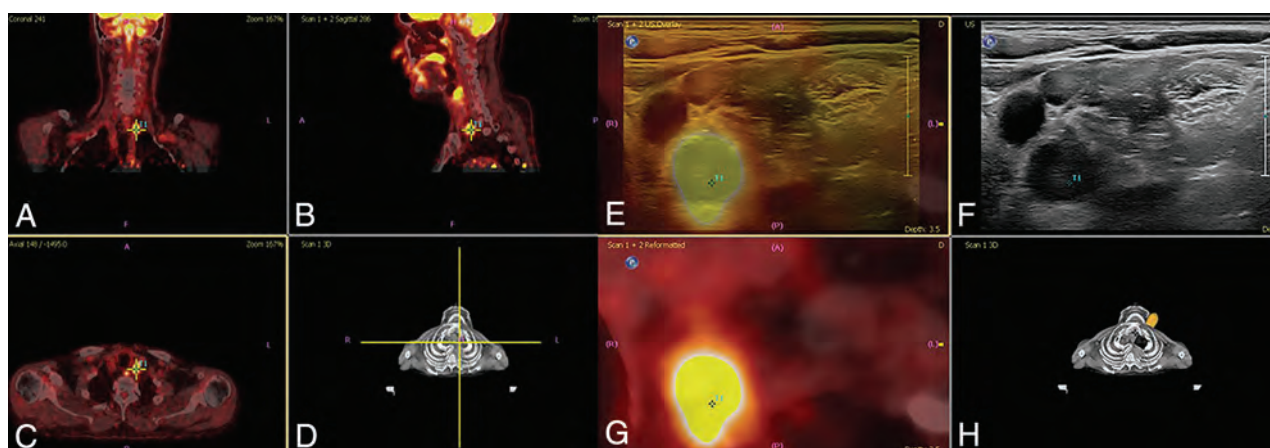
Target planning and real-time fusion of FDG-PET-positive lymph nodes to identify PET-positive nodes. A, Coronal view. B, Sagittal view. C, Axial view. D, Volume representation of FDG-PET/CT image and probe location, PET-positive nodes where targeted, and real-time image fused with ultrasound. E, Overlay US (yellow) and PET/CT (gray). F, US image. G, Reformatted PET/CT image. H, Volume representation of the CT image and probe location. Fusion of PET and CT and target planning took place using the electromagnetic navigation system PercuNav. First, routine ultrasound and routine USgFNAC were performed. Second, ultrasound and FDG-PET-positive nodes were real-time fused. USgFNAC in PET-positive nodes was confirmed, and additional fused-USgFNAC of missed PET-positive nodes was performed.
